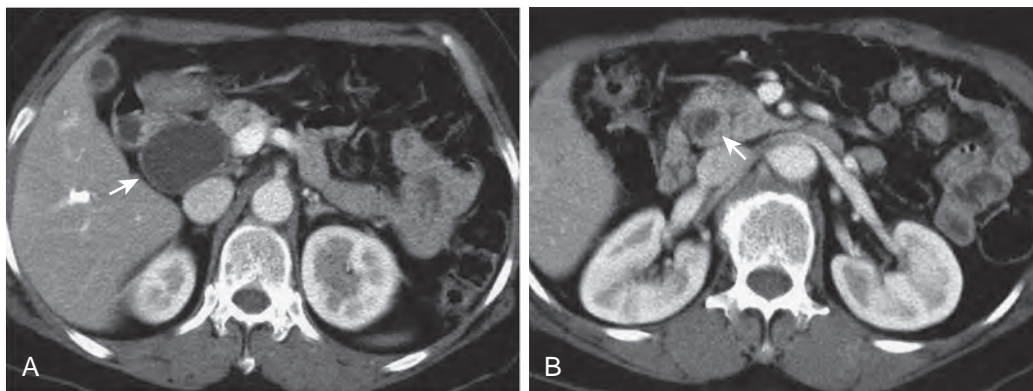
Cholangiocarcinoma complicating choledochal cyst. A. Contrast-enhanced axial CT scan shows a choledochal cyst (arrow). B. CT scan caudal to A shows an asymmetric thickening (arrow) of intrapancreatic common bile duct with enhancement.
